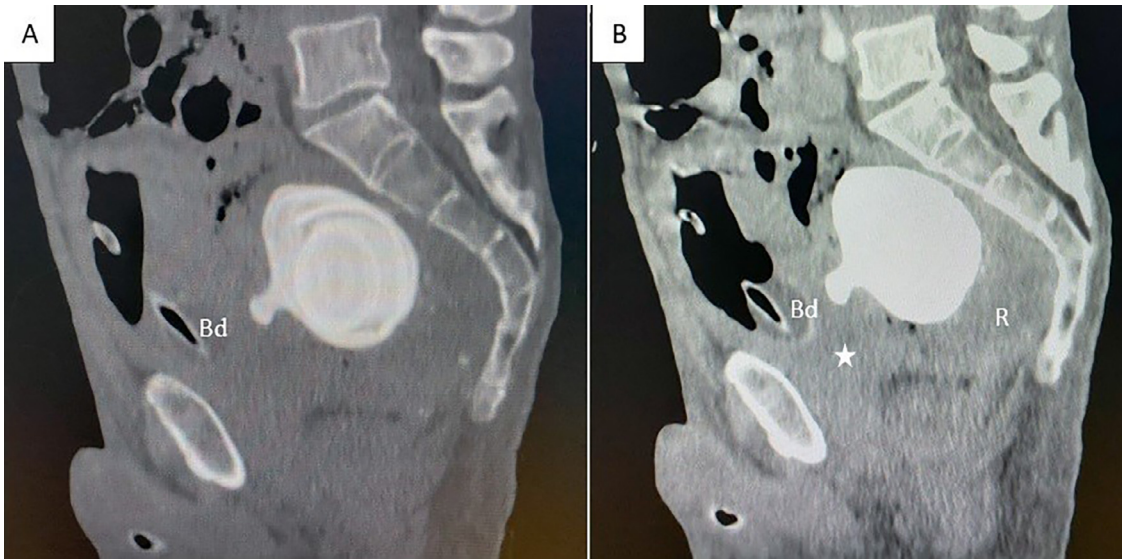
Sagittal sections of the CT scan of the abdomen with a bony window (A) and parenchymal window with contrast product injection (B) showing the migration of the large stone toward the rectum (R) and the rectovesical fistula (white star).
